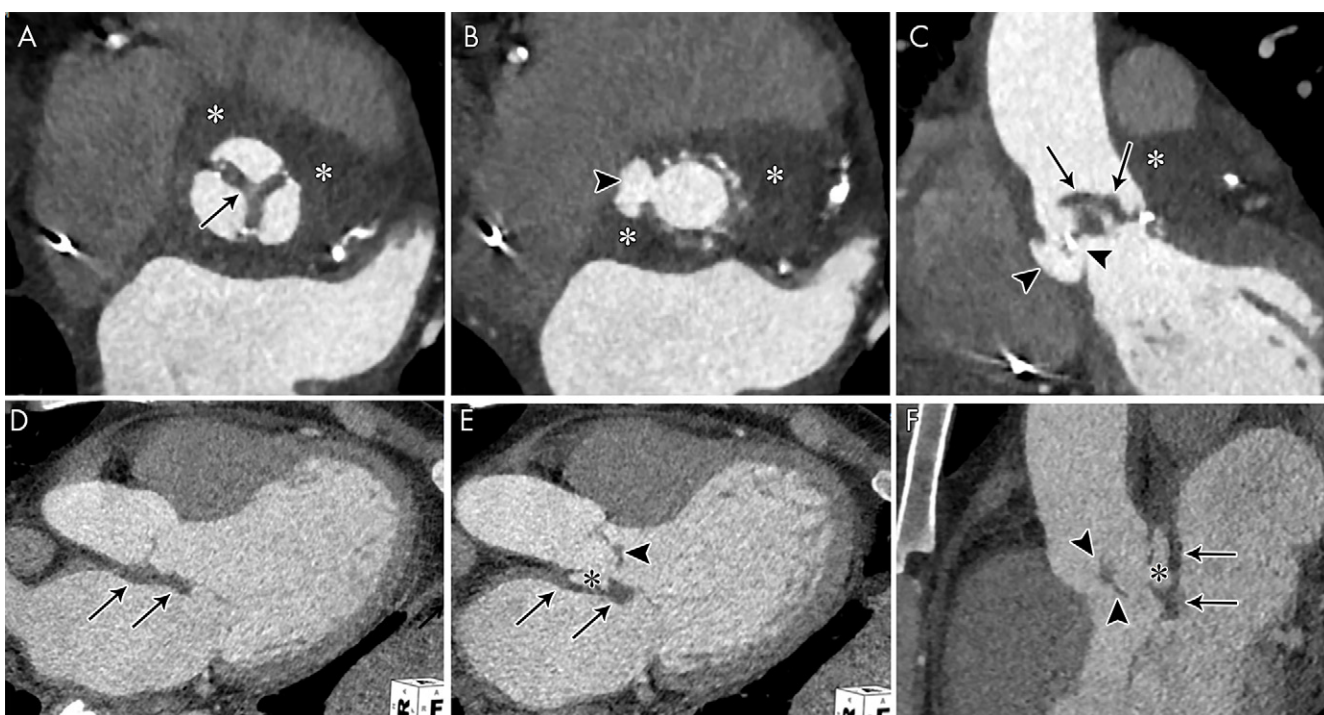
A, B, Short-axis and, C, oblique coronal contrast-enhanced CT images of the aortic valve in an 83-year-old man show bioprosthetic valve leaflet thickening with mobile nodular leaflet hypoattenuation (arrows, Movie 1 [supplement]). There is a large soft-tissue low-attenuation area surrounding the aortic root consistent with a periaortic abscess (*) with left ventricular outflow tract (LVOT) pseudoaneurysm (arrowheads). D, E, Three-chamber and, F, sagittal oblique contrast-enhanced CT images in a 46-year-old man show a nodular attenuation along the valve leaflet with linear attenuation extending into the LVOT (arrowheads), and contrast material-filled pseudoaneurysm (*) arising from the LVOT and extending adjacent to the thickened intervalvular fibrosa and the anterior mitral valve leaflet base (arrows).
